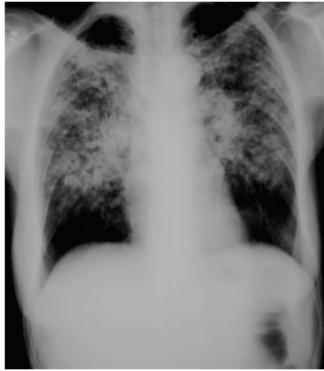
Chest X-ray showing bilateral infiltrates mainly towards the central and upper fields.
